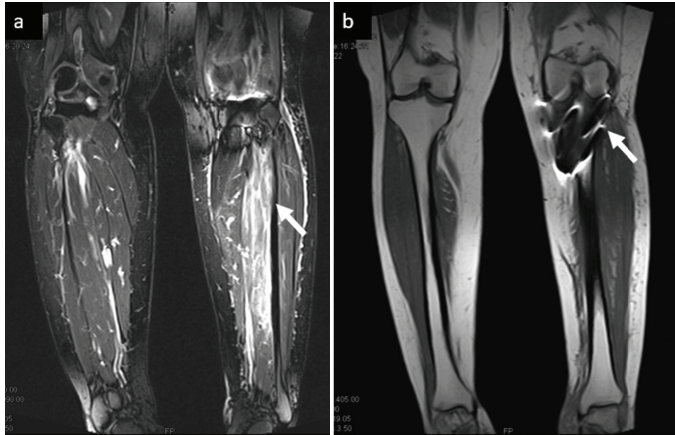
In the same patient, T2-weighted image (a) shows hyperintense signals compatible with extensive edema, and T1-weighted image (b) reveals surgery material on the left crus
